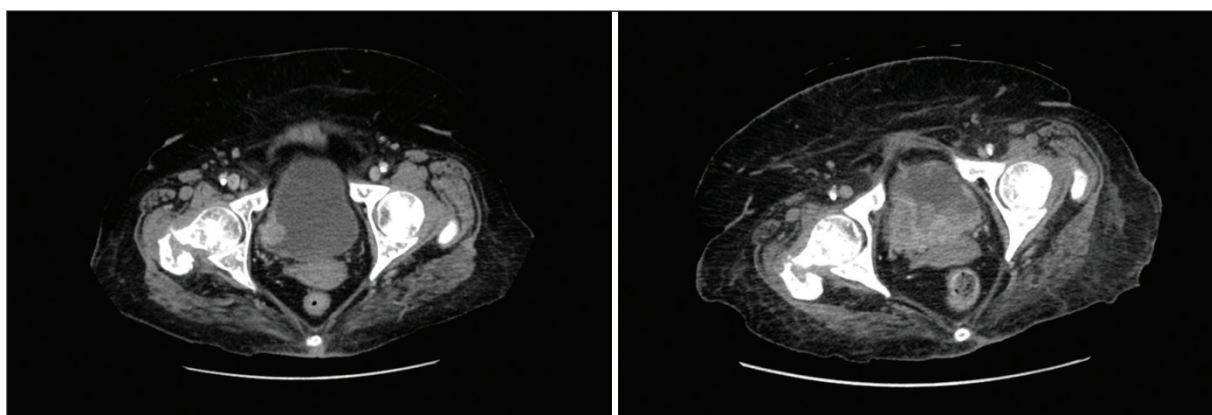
(A) Initial axial computed tomography (CT) scan showing a subtle nodule within the right aspect of the urinary bladder (Case 1) and (B) followup CT showing significant disease progression (Case 1).
